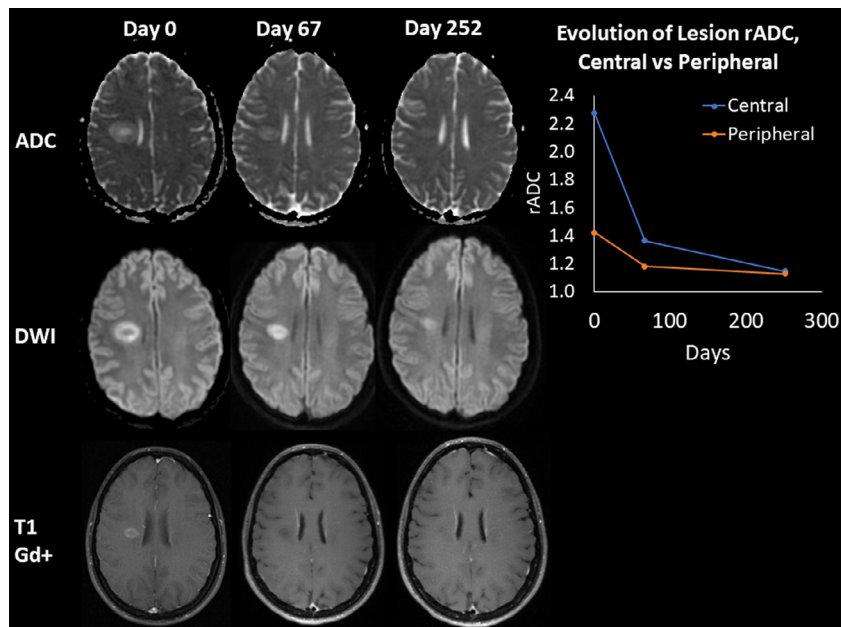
Evolution of Baló concentric sclerosis over time. Axial diffusion weighted imaging, apparent diffusion coefficient (ADC) map, and postcontrast T1-weighted images of the lesion acquired at presentation (Day 0), Day 67, and Day 252 show evolution of diffusion changes and contrast enhancement with time. Graph of relative ADC over time shows relatively reduced diffusion in the periphery compared to the central part of the lesion. This was most pronounced at presentation, decreased but still present at Day 67, and nearly resolved at Day 252.
